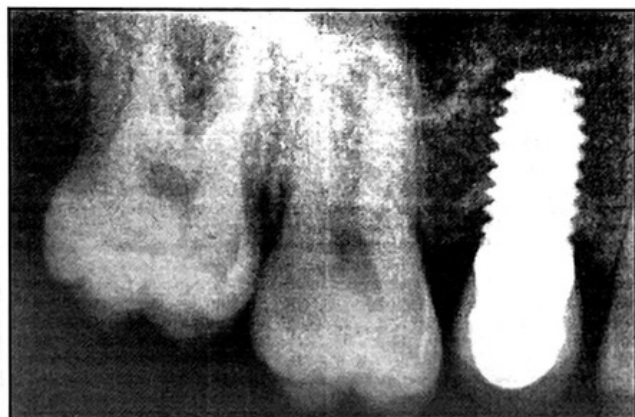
Periapical radiographs of implant #4 after 10 years of loading.
